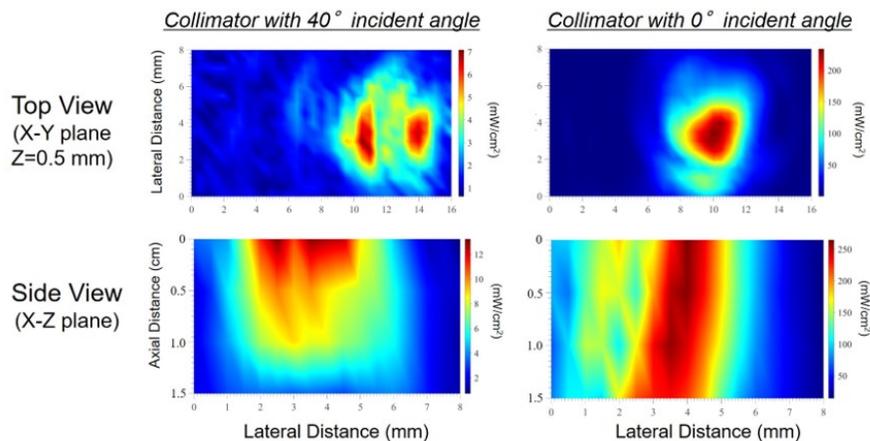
A comparison of ultrasound spatial profiles at different incident angles.
